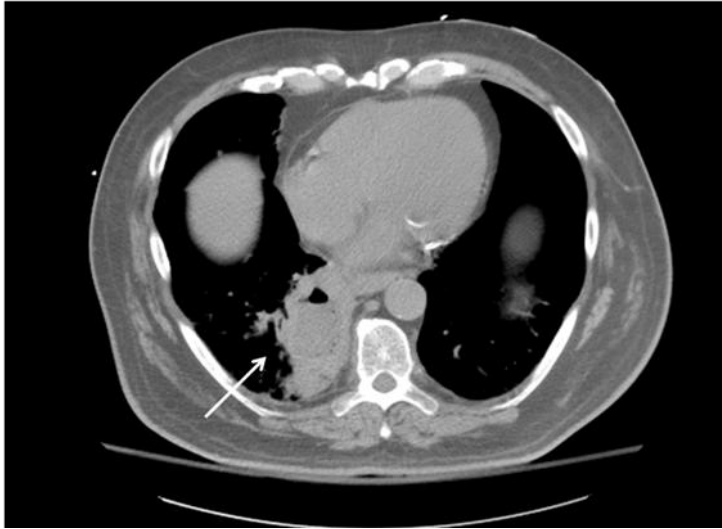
CT scan done 22 months after original CT scan showing cavitation and an air fluid level indicated by the arrow.
